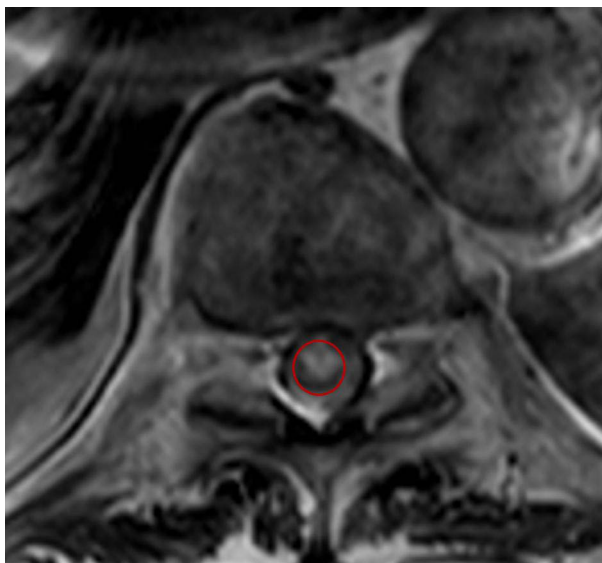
Axial T2-weighted MRI of the lumbar spine demonstrating the classic “owl’s eye” appearance, with bilateral, symmetric T2 hyperintensities in the anterior horn regions, highlighted within the red circle.
